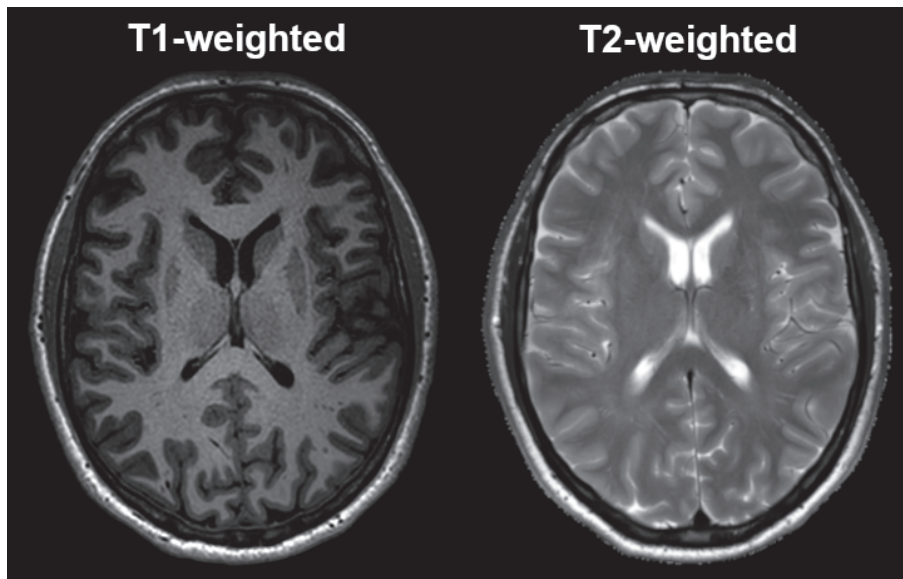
Example of T1-weighted (left) and T2-weighted (right) images. T1-weighted images are taken with short TR and TE, in this case 5.2 and 2.3 ms, respectively. On T1-weighted images, gray matter is darker than white matter, and cerebrospinal fluid is completely dark. T2-weighted images are taken with long TR and TE, in this case 3000 and 80 ms, respectively. On T2-weighted images, gray matter is brighter than white matter, and cerebrospinal fluid is very bright. Here, the T2-weighted image has a higher in-plane resolution than the T1-weighted image.
